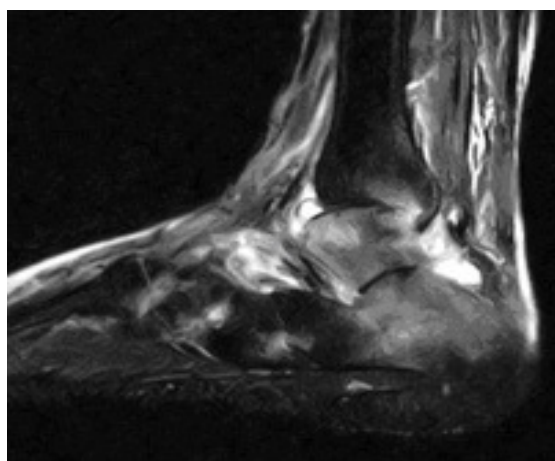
MRI. Acute arthritis of ankle-joint.
